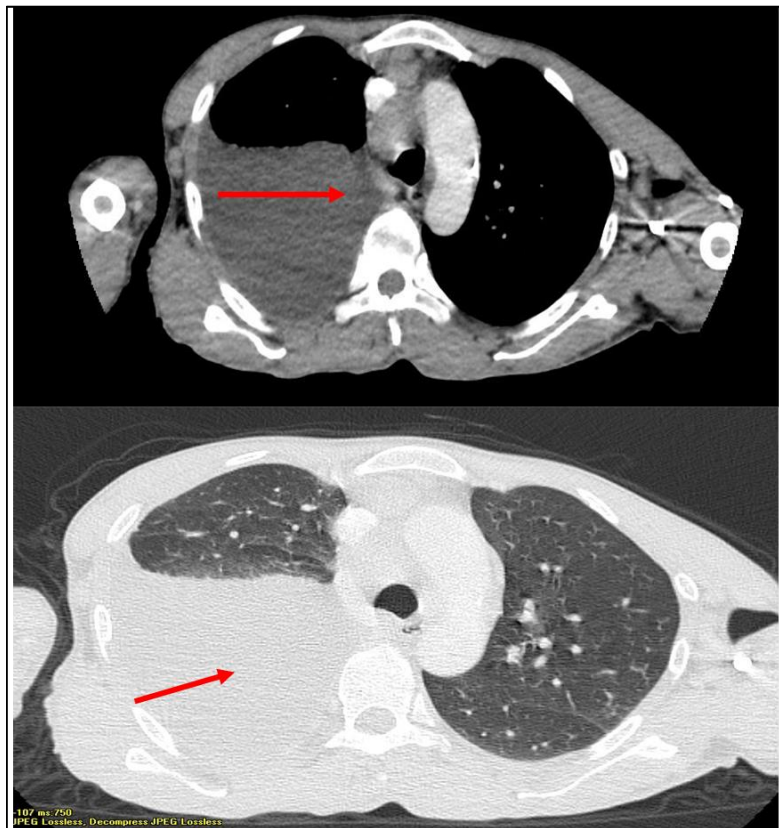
Thoracic CT scan showing mediastinal and parenchymal cuts revealing a moderate right-sided pleural effusion with passive atelectasis of the adjacent pulmonary parenchyma and nonspecific pulmonary micronodules
